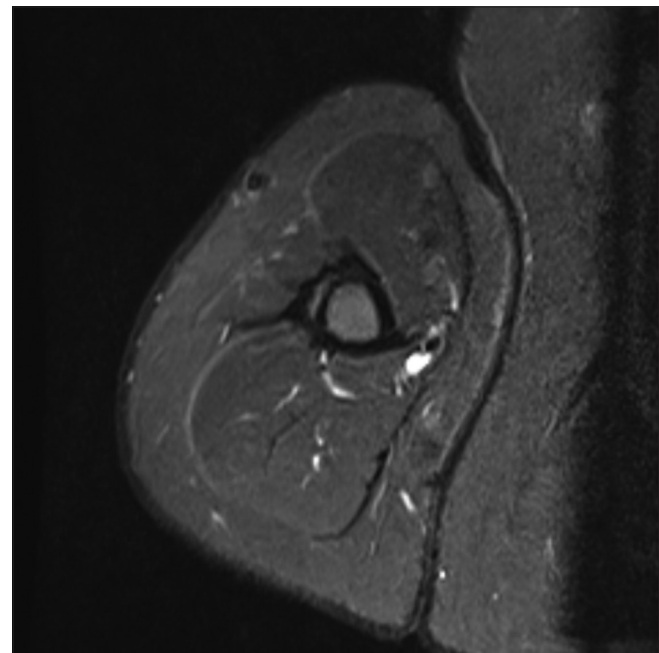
2 months follow-up image shows no significant change in the MRI findings
